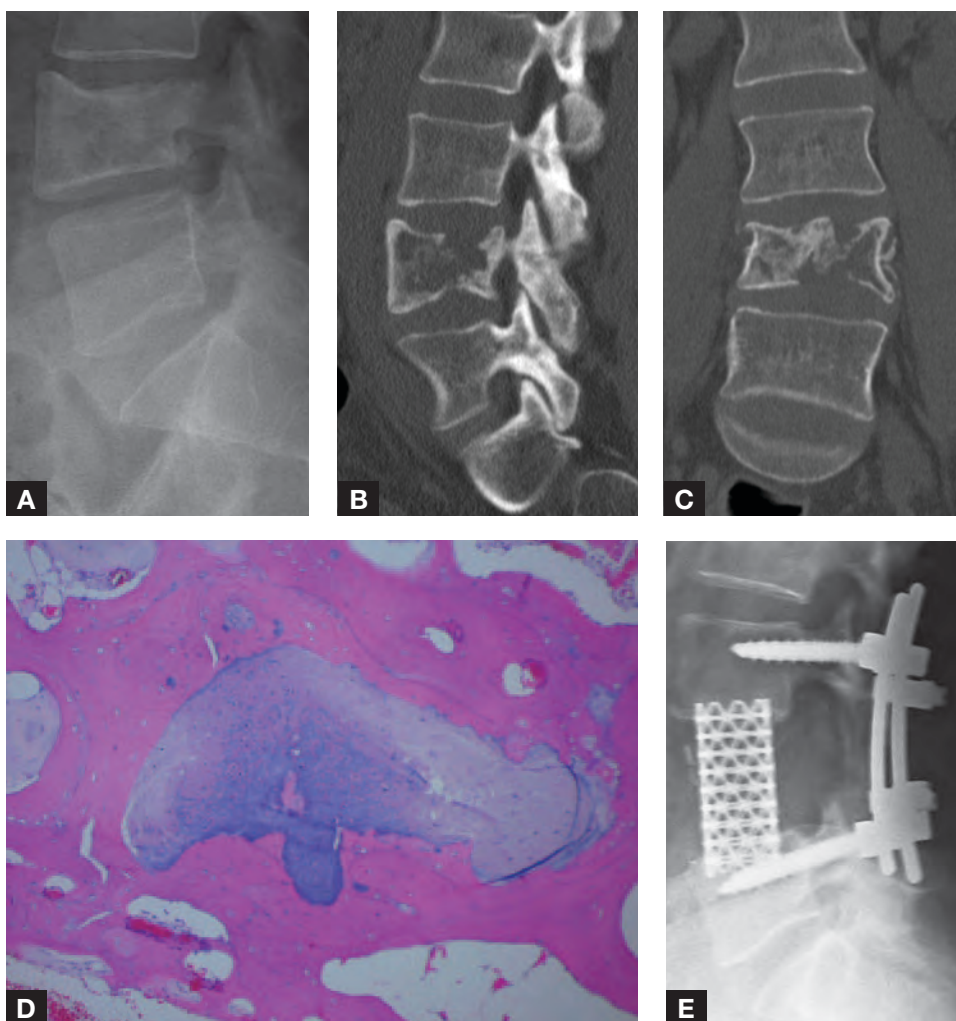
(A) Lateral radiograph showing pathologic fracture of L4. Sagittal (B) and coronal (C) CT reconstruction delineating extent of vertebral body destruction. (D) Biopsy showed intervertebral disc and attached hyaline cartilage endplate into the vertebral body with abundant callus formation. (E) Follow-up postoperative lateral radiograph.
